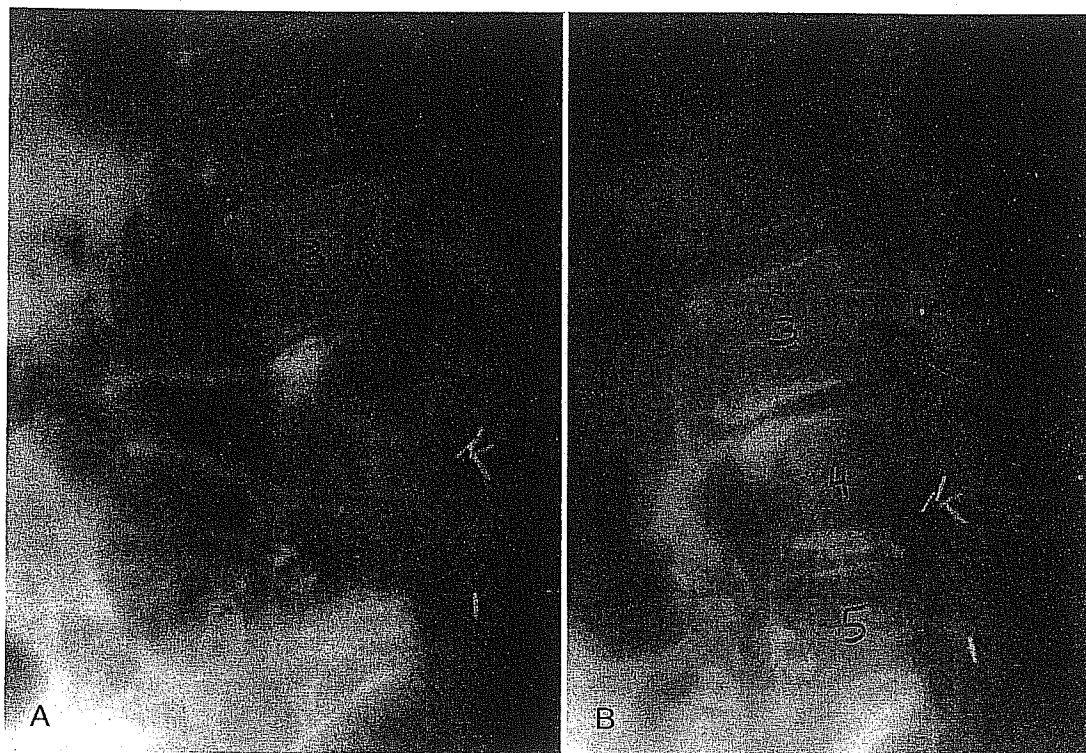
A 60-year-old patient developed instability at the L3–L4 level 2 years after undergoing an L4–S1 floating fusion for instability at the L4–S1 levels. (A) Lateral x-ray of the lumbar spine
